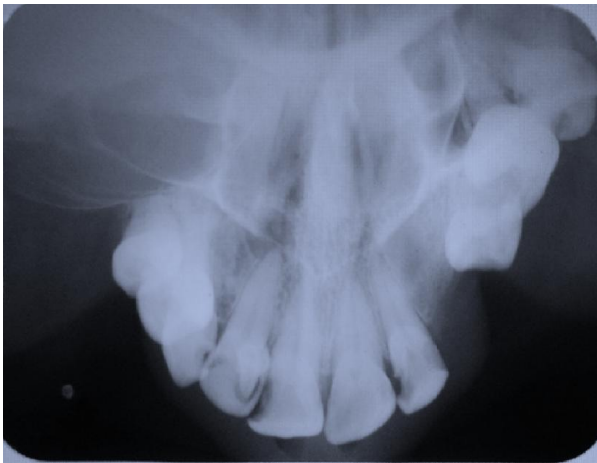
Maxillary occlusal radiograph showing opacification of right maxillary sinus with loss of bone and extension of cystic space into buccal cortex posterior to the second premolar
